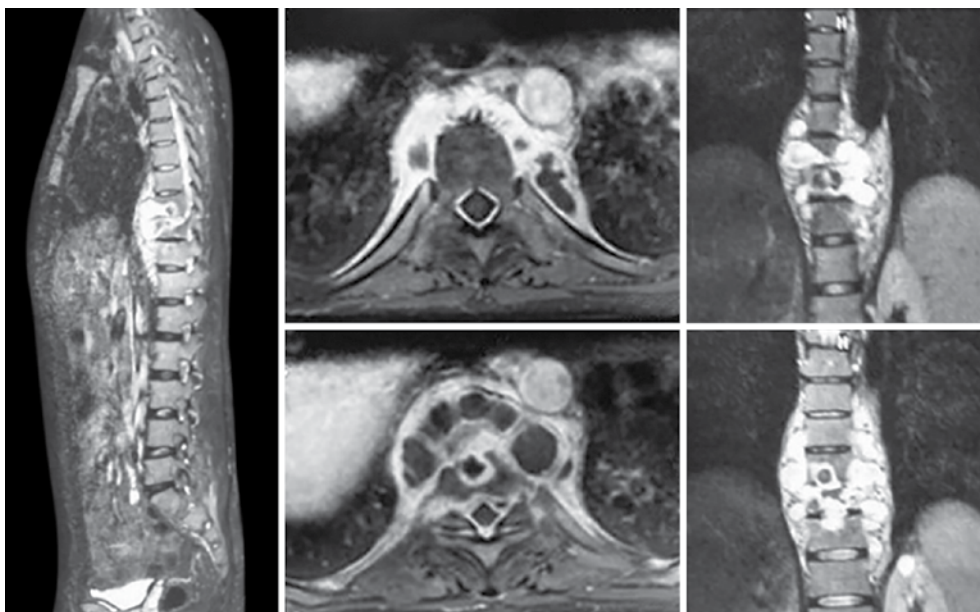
Magnetic resonance imaging images showing the paradiscal involvement and extent of abscess
